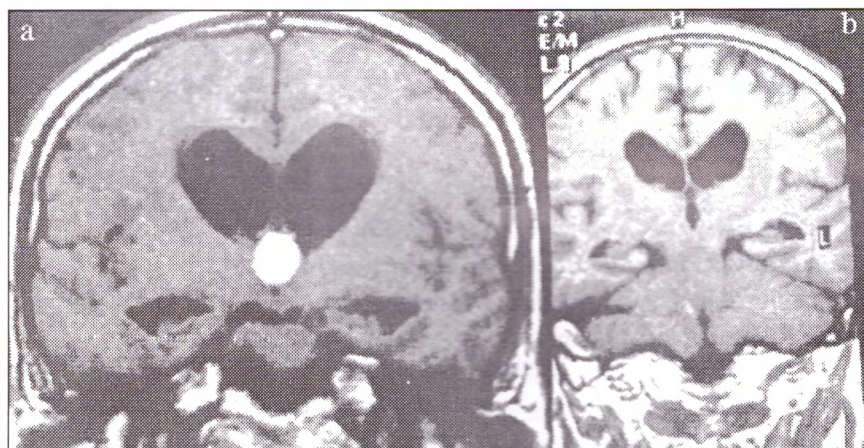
MRI of a patient with colloid cyst of the III ventricle before /a/ and after /b/ endoscopic excision of the cyst, reduction of the internal hydrocephalus is noted.
